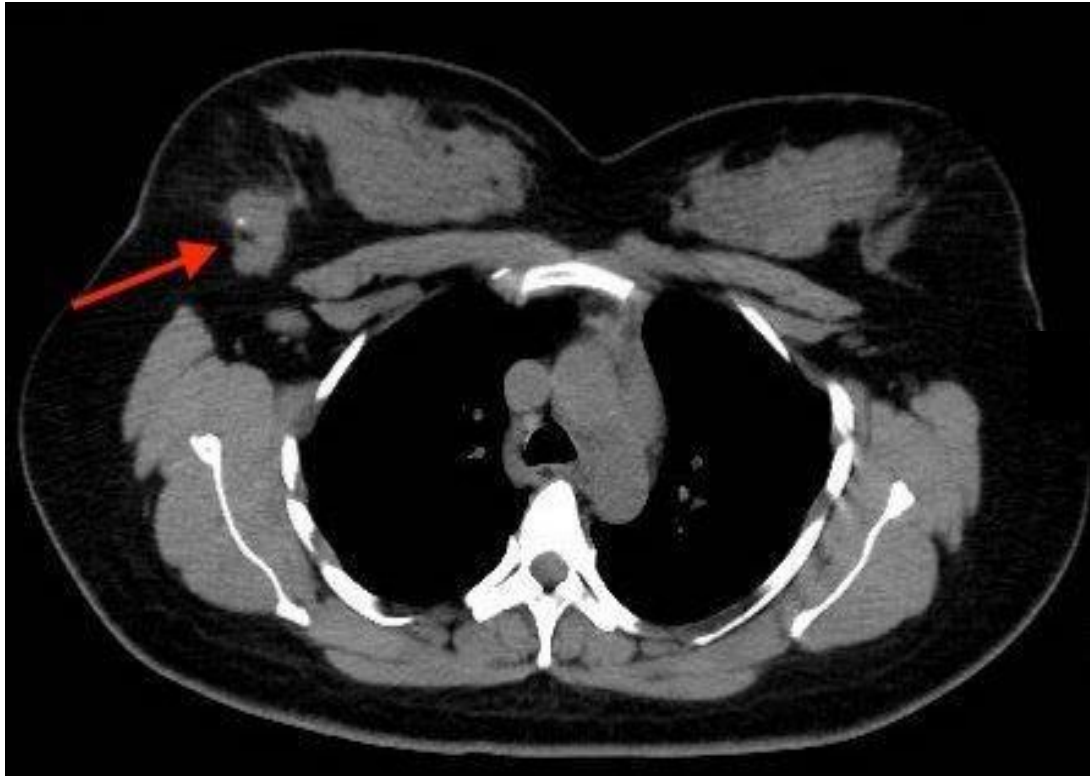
A CT scan showing a soft tissue density (arrow) in the region of the suspected mass.
